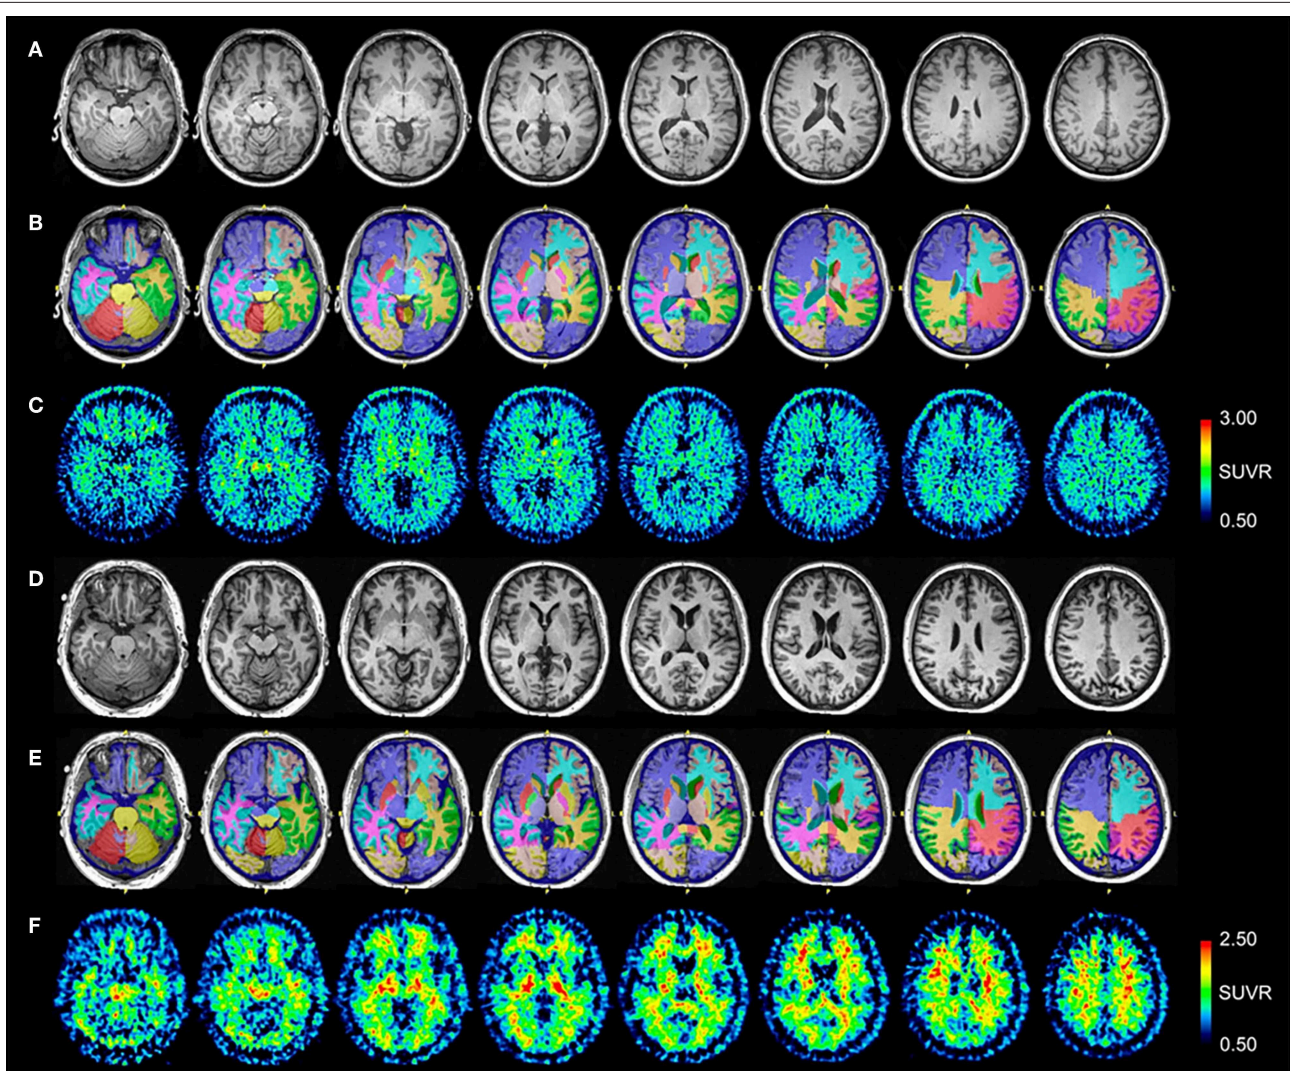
Serial transverse brain sections from (A) structural MRI, (B) NeuroReader segmentation, and (C) [^{18}F]AV-1451 PET scans for Control #1; and (D) structural MRI, (E) NeuroReader segmentation, and (F) [^{11}C]PiB PET scans for Control #2. SUVR color bar scales for each PET radiotracer are identical across all patients and controls. The [^{18}F]AV-1451 image for Control #1 shows mild basal ganglia, substantia nigra, and choroid plexus uptake that reflects a typical pattern of off-target binding. By comparison with both patients, there is negligible occipital, frontal, temporal, and parietal lobe uptake. The [^{11}C]PiB image for Control #2 shows non-specific uptake in white matter regions, but negligible uptake throughout neocortical and subcortical gray matter.
